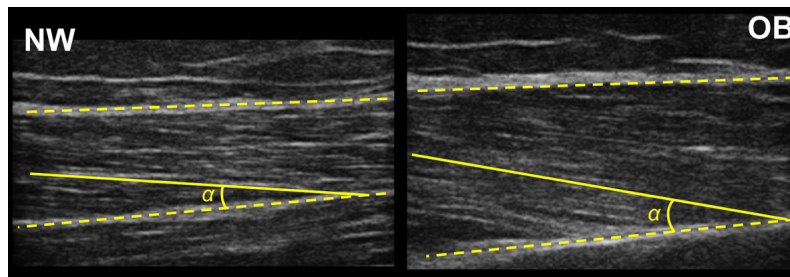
Rectus femoris* architecture in a normal-weight (NW) and obese (OB) woman obtained with B-mode ultrasonography imaging. Yellow broken lines represent superficial (upper line) and deep (lower line) aponeurosis; solid yellow line represents muscle fascicle orientation; the angle of insertion of muscle fascicles on deep aponeurosis (pennation angle) is indicated as α . The image evidences the muscle architecture difference detected between OB and NW individuals (data from (79)).
